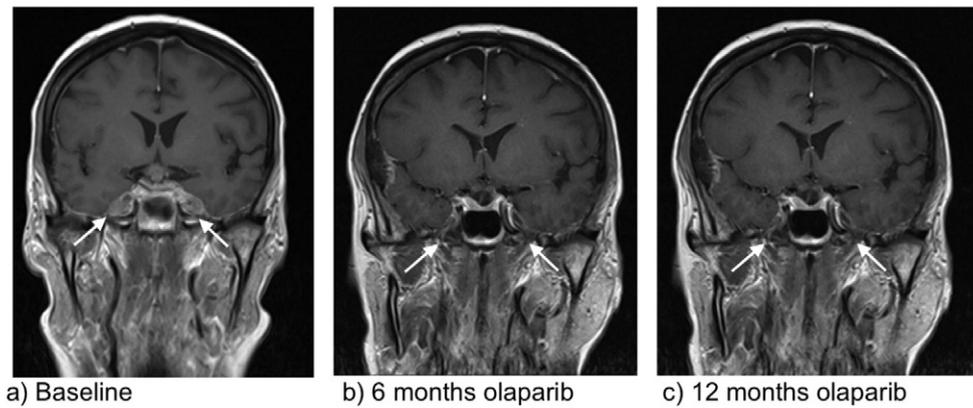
MRI brain scans demonstrating response of skull base leptomenigeal disease to olaparib (T1 weighted, post gadolinium contrast, coronal sections): a) Enhancing skull base leptomenigeal disease pre-olaparib. b) Significant decrease in volume and enhancement of skull base leptomenigeal disease after 6 months of olaparib. c) Unchanged significant decrease in volume and enhancement of skull base leptomenigeal disease after 12 months of olaparib.
